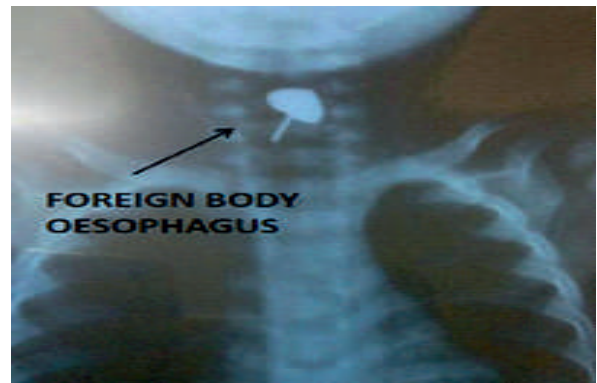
X-ray neck showing a foreign body with sharp end directed caudally and blunt end directed cranially.
